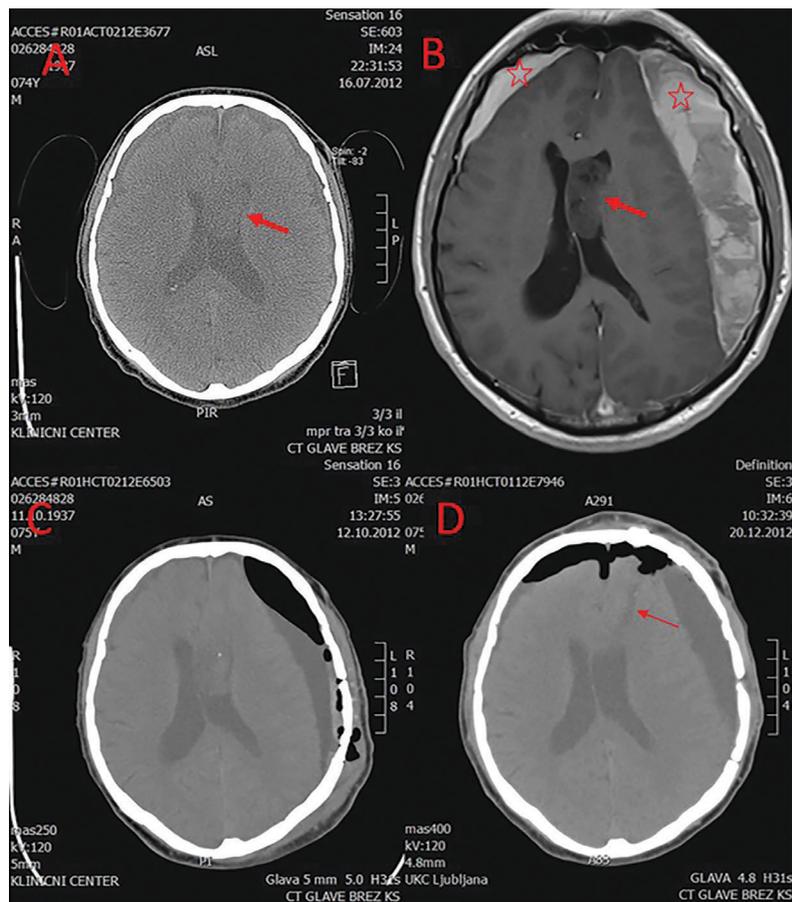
Initial CT revealed an accidental tumour in the left horn of the lateral ventricle (thick arrow) (A). An MRI two months later revealed chronic subdural hematomas bilaterally (star). On the left side, the haematoma is compressing the brain and causing the brain shift across the midline (B). Control CT scan after the left haematoma evacuation. On the left side, some air and fluid are still present as the brain tissue has still not expanded completely. The tumour can be seen in the left lateral ventricle (C). The last CT shows the situation 24 hours after the endoport removal of the tumour. The trace of the endoport is barely visible (thin arrow) (D).
